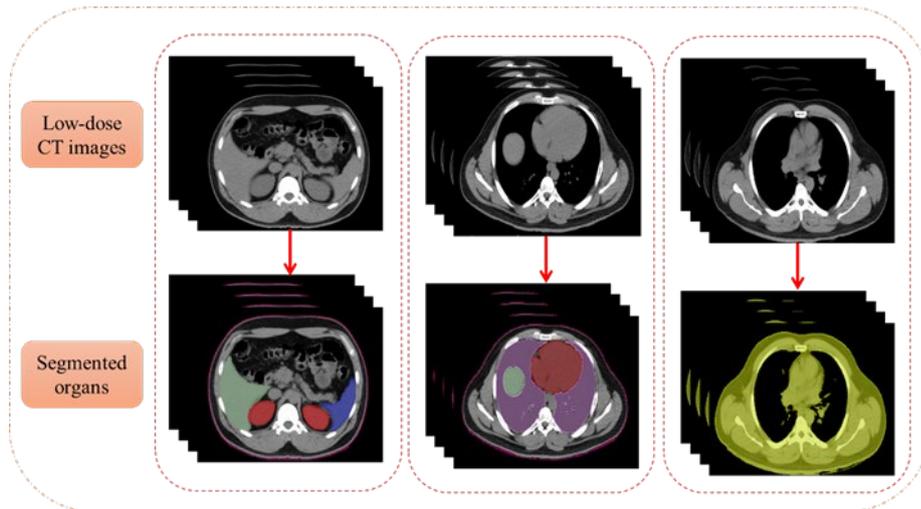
Segmentation of the organs of interest on PET/CT images.
